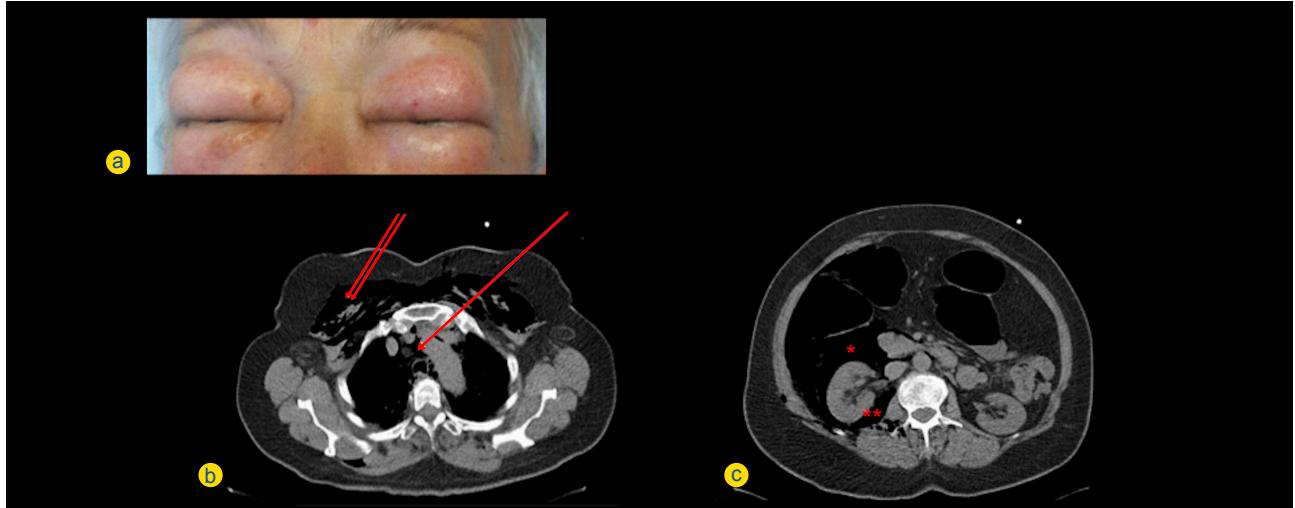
a) Patient with emphysema in the face and eyelids. b) Chest CT scans where you can see pneumomediastinum (arrow) and subcutaneous emphysema (double arrow). c) Abdominal CT scans where you can see pneumoperitoneum (*) and retropneumoperitoneum ().
